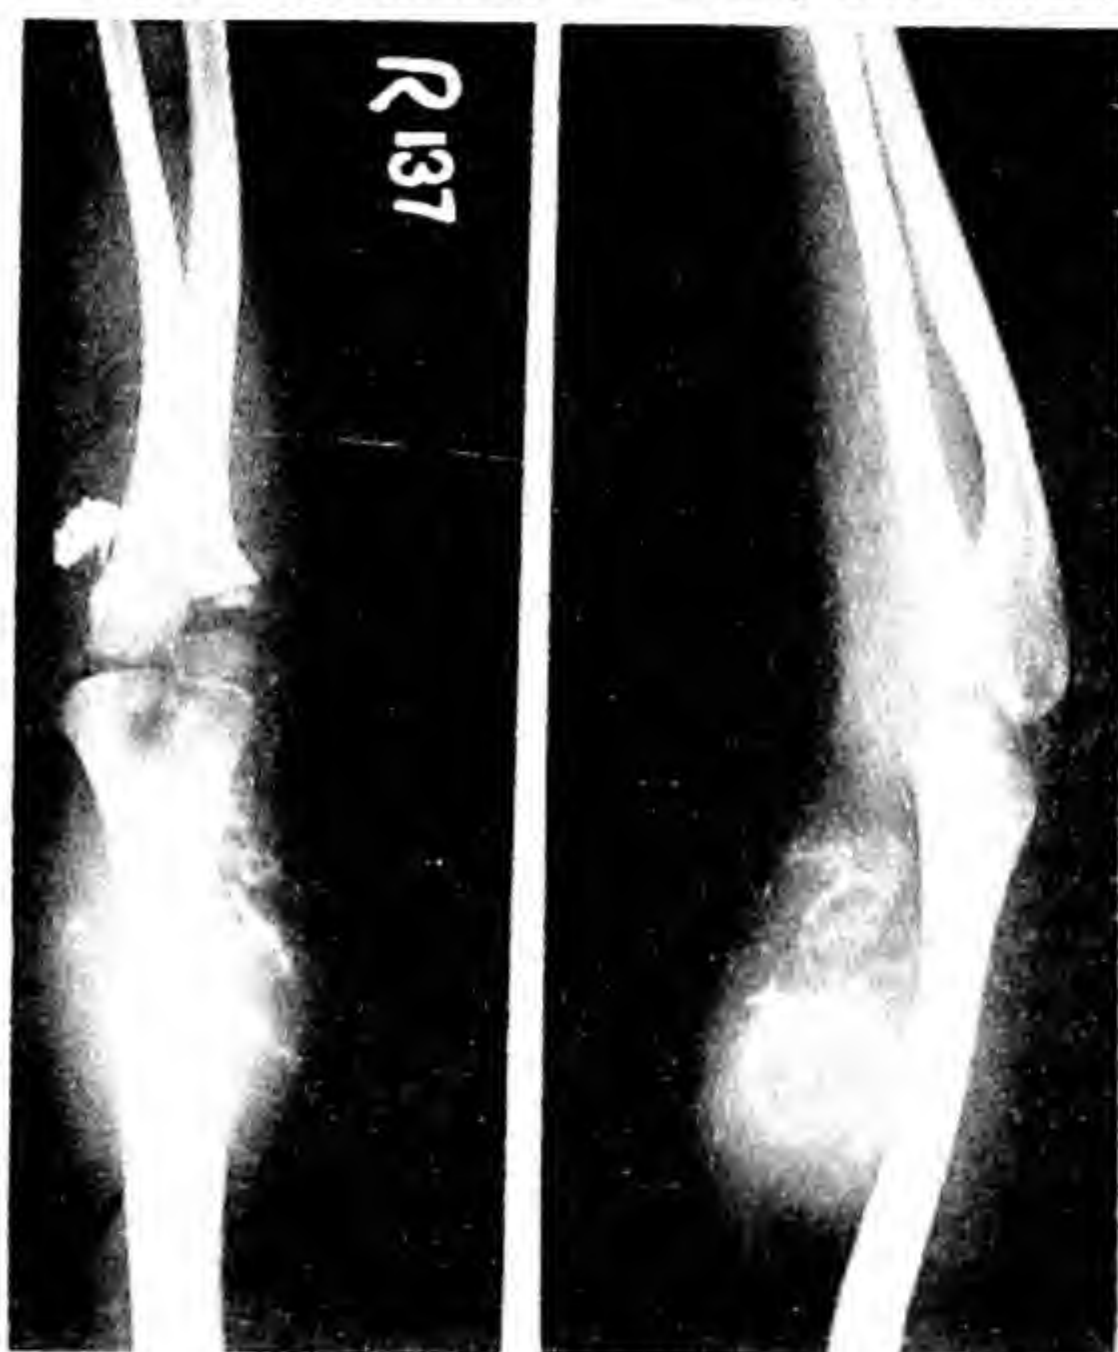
X-ray lower arm with elbow showing soft tissue swelling anteriorly with diffuse calcification and ossification of the tumour and scalloping of the underlying bone.
